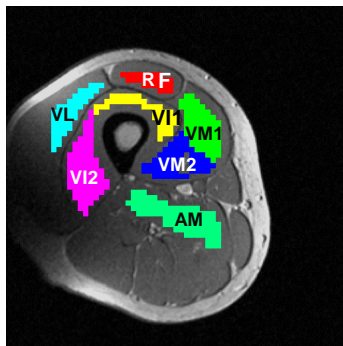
Manual segmentation of the thigh, overlaid on a co-registered MR image. Segmented muscles included m. rectus femoris (RF), m. vastus medialis (VM), intermedius (VI), lateralis (VL), and m. adductor magnus (AM). VM and VI were divided into two parts, each.
